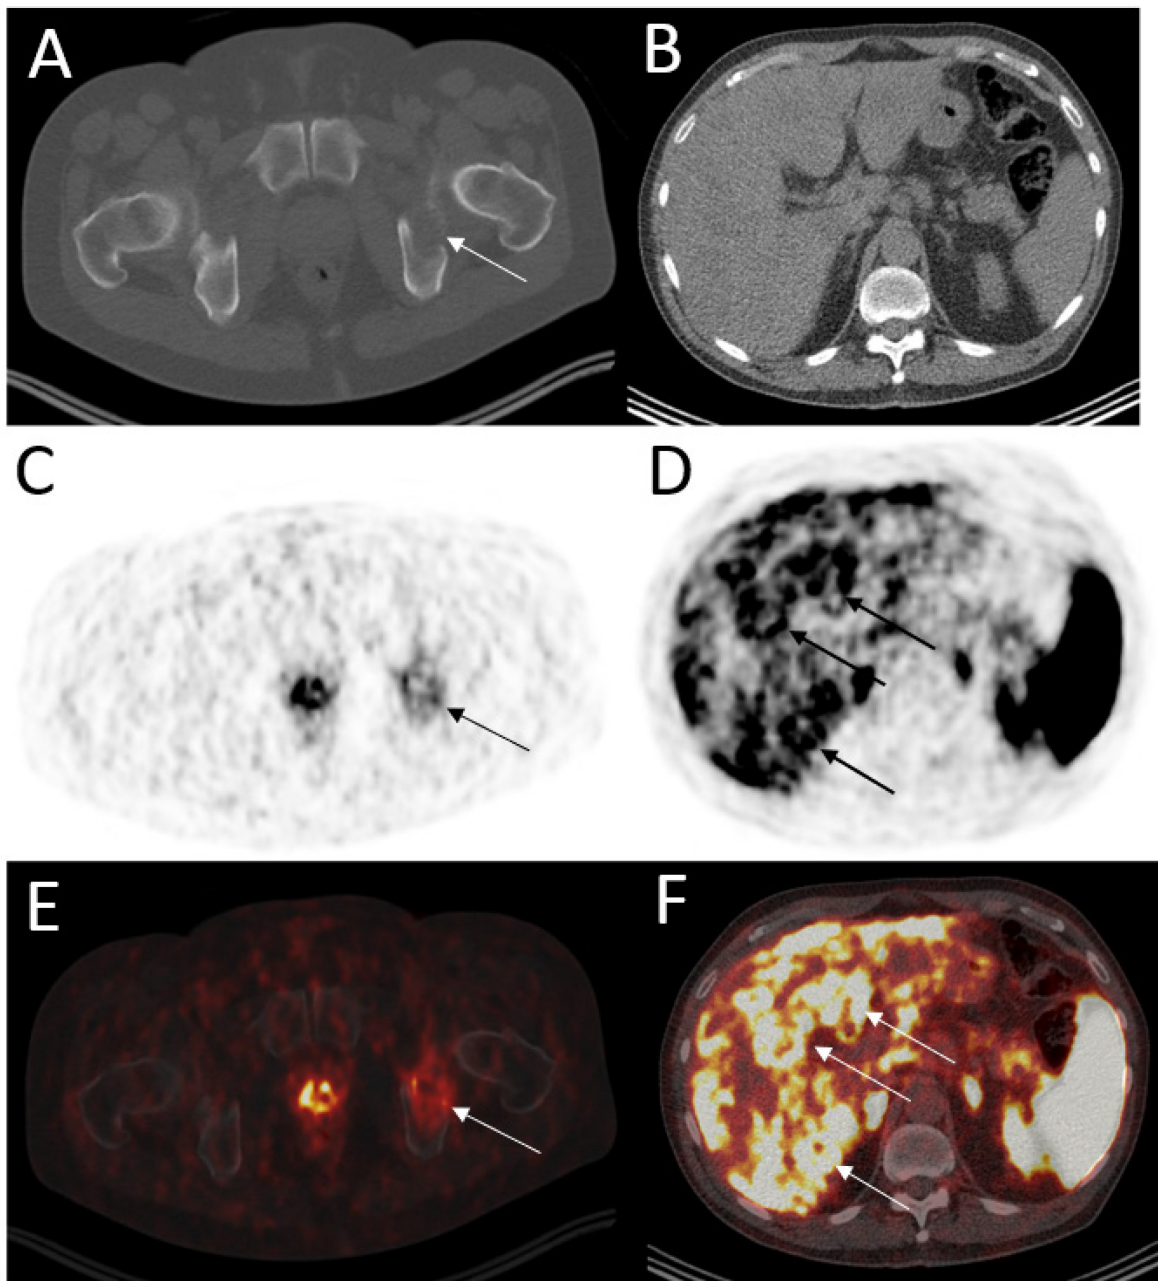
G3 NET metastases with colon as primary site, which was removed prior to the examination. A: CT image with bone window. The arrow indicates a secondary lesion in the hip bone (acetabulum) B: CT image of the liver. The liver imposes without distinctive lesions, contrary to D and F. C: PET image, same slice as A. The secondary tumor site in the hip bone shows tracer uptake. D: PET image, same slice as B. The arrows indicate multiple metastases with tracer uptake in the liver. E: Fusion image of the hip. The secondary lesion is visible in CT and PET imaging. F: fusion image of liver metastases. The arrows indicate areas which show secondary tumor lesions. PET and CT imaging combined can show the anatomical localisation of the metastases which were not visible in CT alone.
